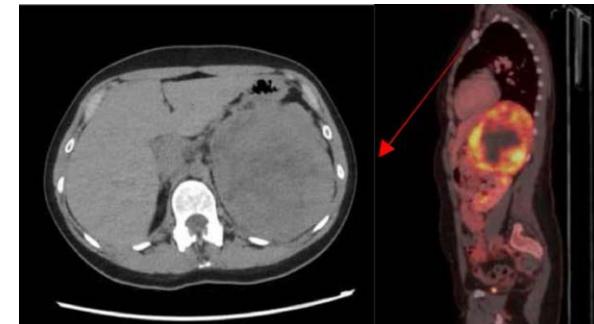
CT-scan without contrast enhancement (left): giant mass of 13 cm at the left hypochondrium. PET-CT(right): FDG-avidity with central necrosis.
